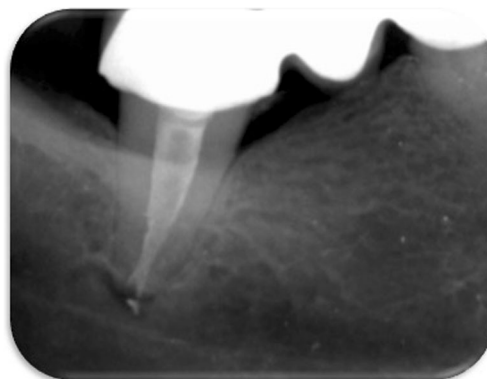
Case #2 radiographic assessment with a 6-month follow-up
